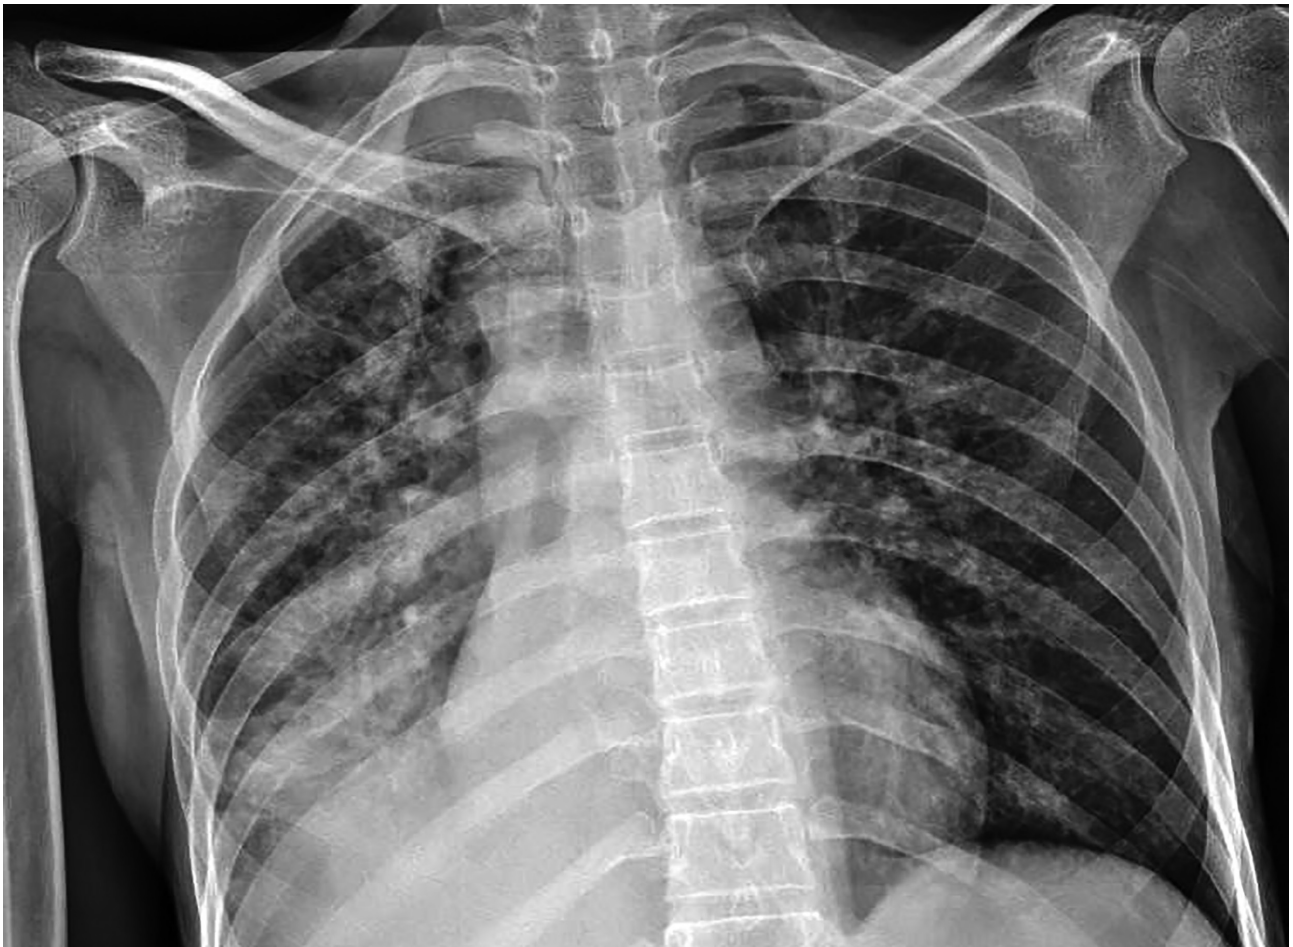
Pulmonary X-ray of the reported case thirteen days after admission.
